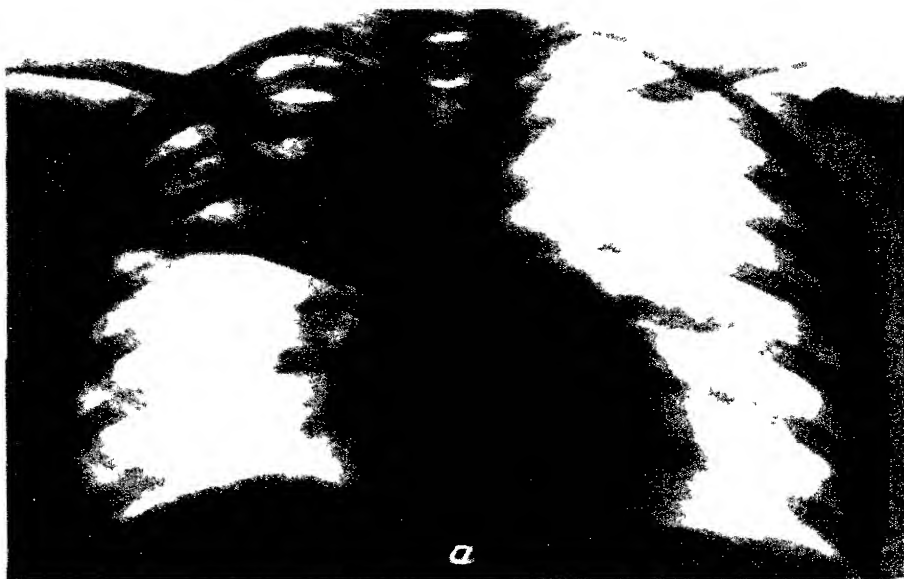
X-rays of patient X
